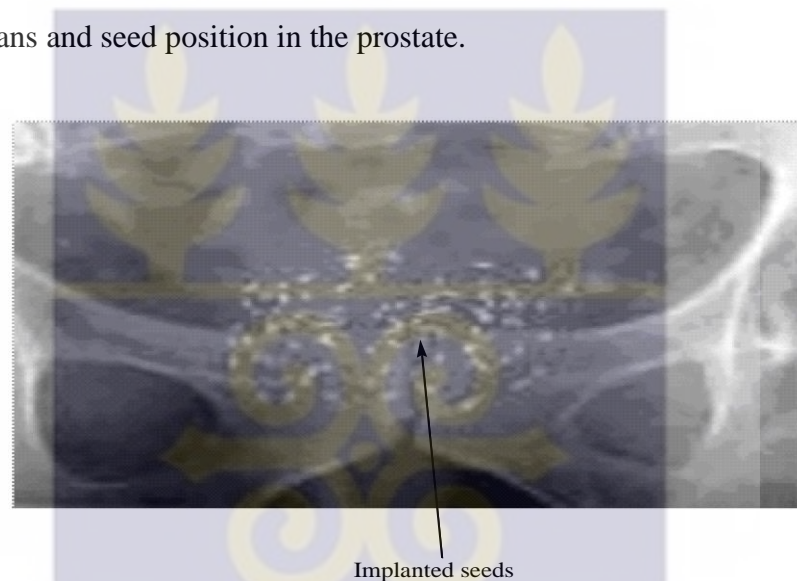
CT image after I-125 seeds implant, this is done four weeks after the procedure.
